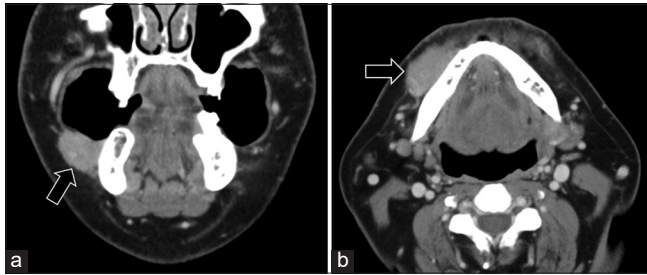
Right buccal marginal zone lymphoma in a 58-year-old male. Coronal (a) and axial (b) contrast enhanced images of the CT neck showed enhancing right buccal submucosal mass with involvement of the inferior gingivobuccal sulcus (arrows).
